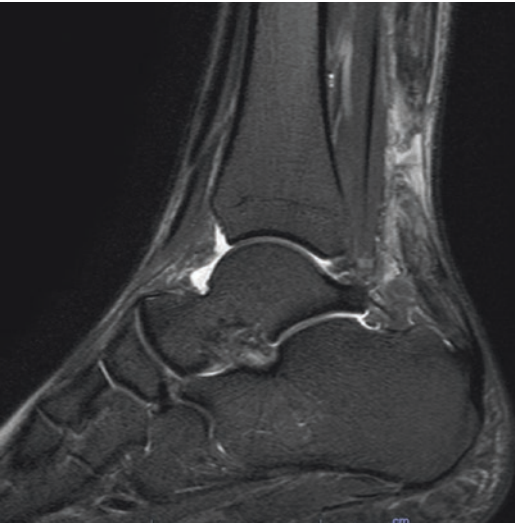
MRI of the ankle demonstrates an acute Achilles rupture at its midsubstance. Gapping is noted between the tendon edges
